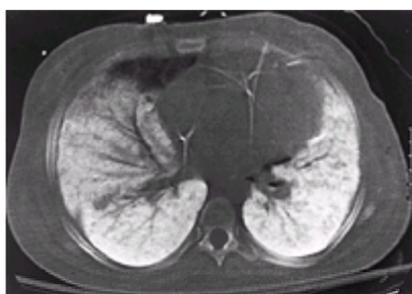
Computed tomographic scan of a patient with ARDS receiving partial liquid ventilation with Perflubron. (Reprinted with permission from Marini JJ. Evolving concepts in the ventilatory management of acute respiratory distress syndrome. *Clin Chest Med* 1996;17:555–575.)
